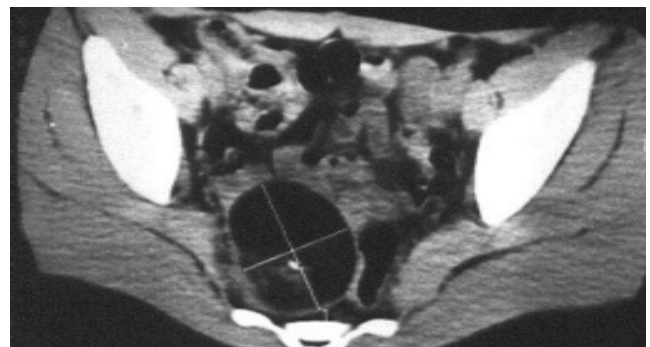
CT scan of the pelvis showing solitary cystic, retrorectal tumor.
